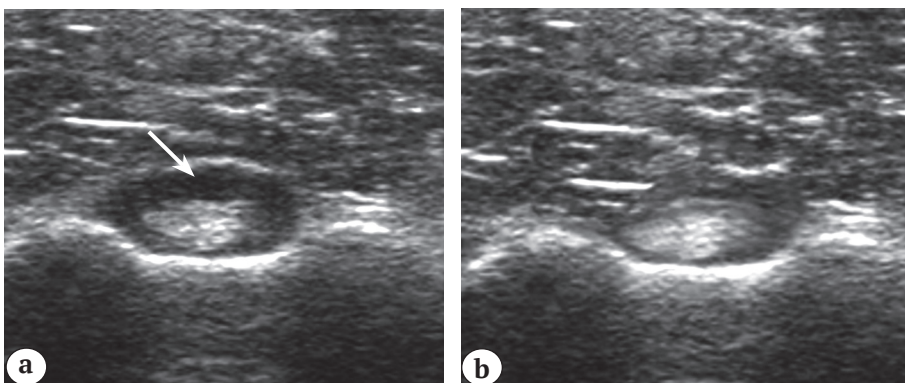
Changes in echogenicity of LHB tendon on ultrasound (indicated by arrow) (7.5 mHz, linear probe):
